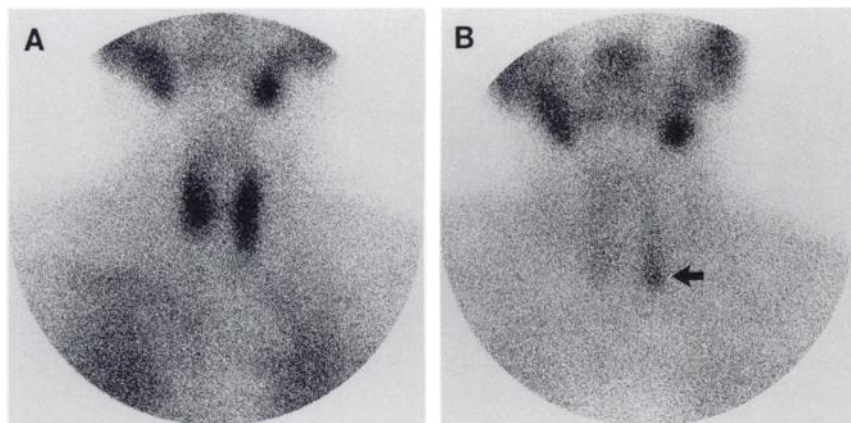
(A) The early ^{99m}Tc -sestamibi scintigraphy shows a normal and relatively uniform thyroid uptake. (B) However, on delayed imaging (2.5 hr), there is an increased focal uptake in the left lower neck corresponding to a parathyroid adenoma (300 mg) at this level (arrow).
